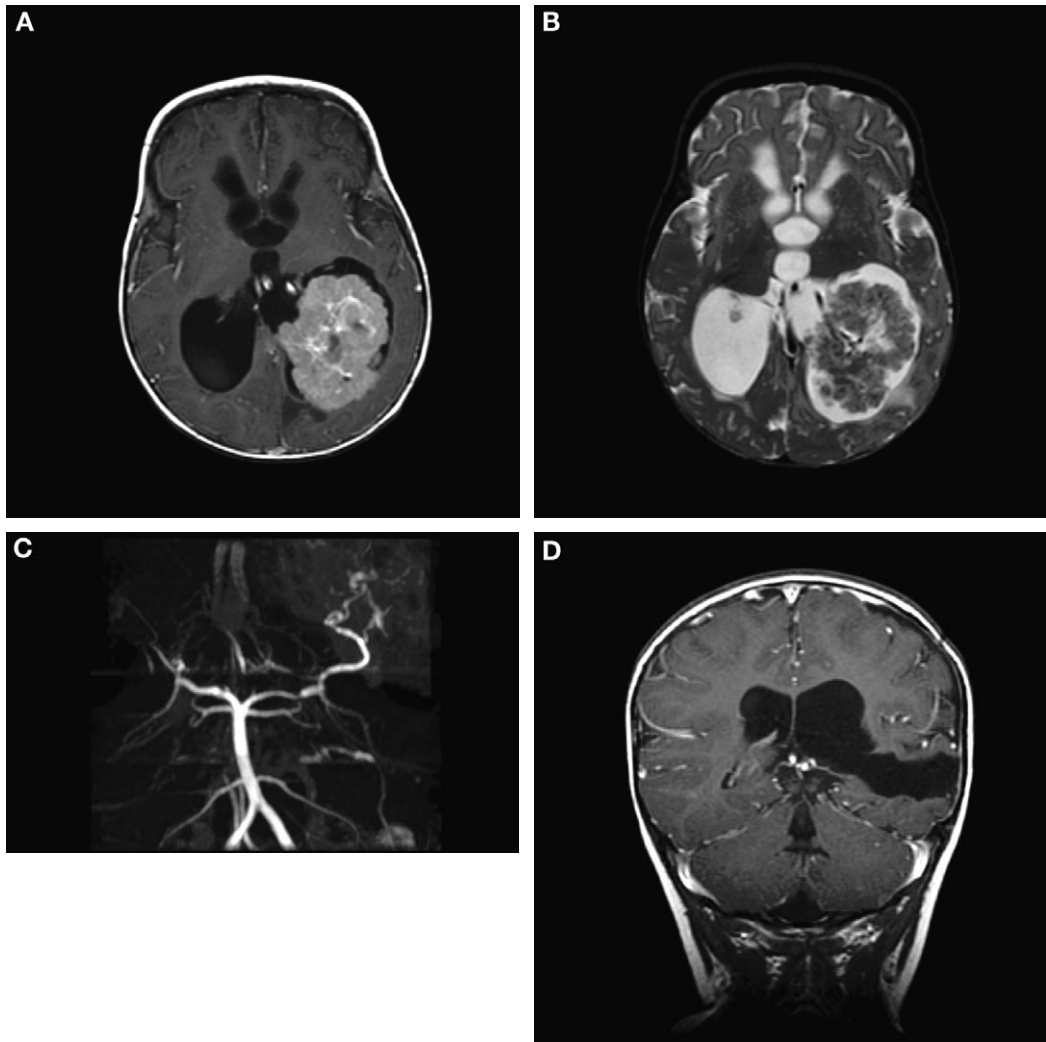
An 18-month-old girl with a large left ventricular choroid plexus papilloma. (A) T1-weighted image after injection of gadolinium. (B) T2-weighted axial image. (C) MR angiogram demonstrating a choroidal artery arising from the posterior cerebral artery leading to the tumor. (D) A postoperative, coronal, T1-weighted image demonstrating the surgical route clearly shows an enlarged choroidal artery leading into the tumor. Postoperative coronal MRI demonstrates the route through the temporal lobe used to access the feeding artery initially and then the actual tumor itself.
